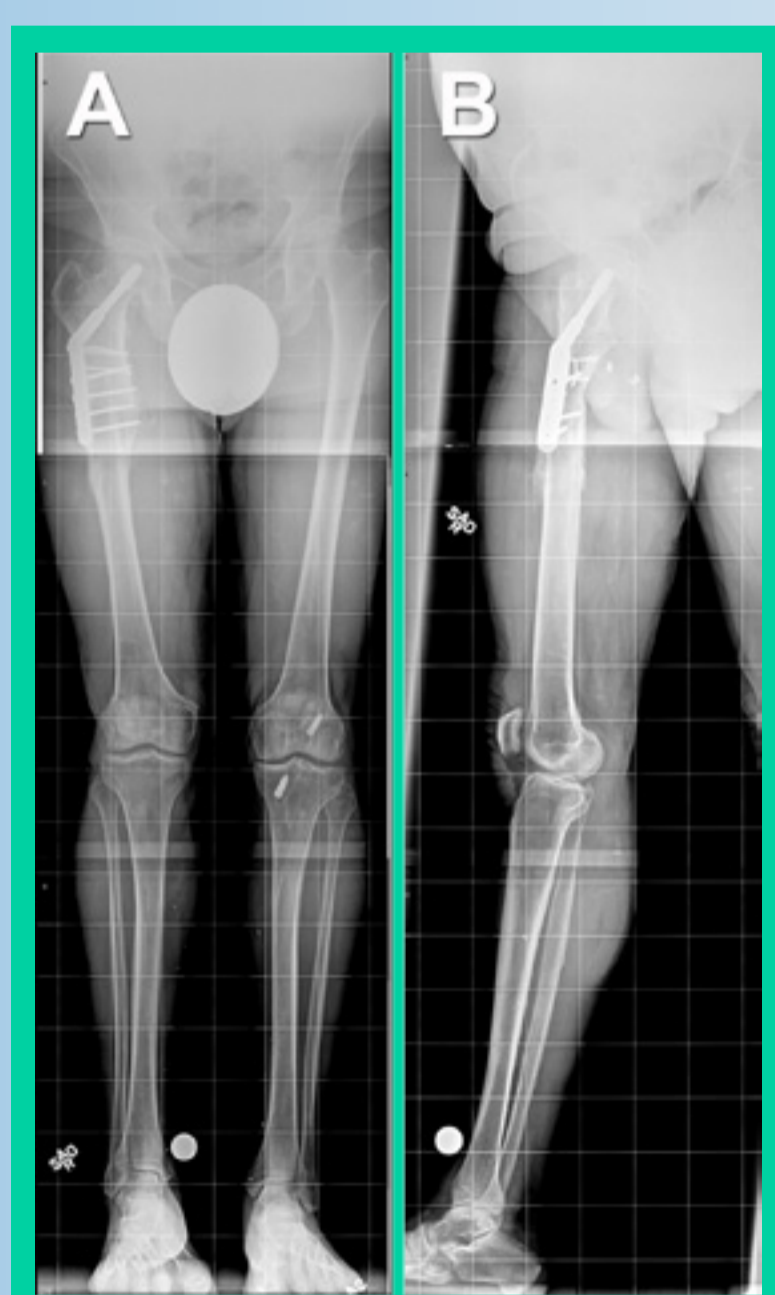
Posttraumatic femoral deformity in a 71-year-old patient (case number 5 in Table 1). Preoperative AP (A) and lateral (B) view radiographs of the affected femur before insertion of the motorized magnetic lengthening nail.
